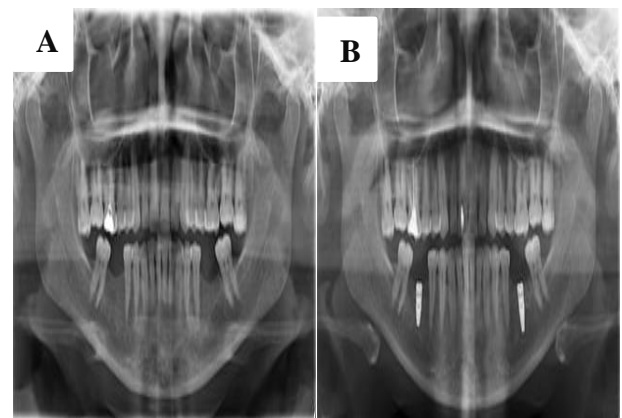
(A and B) Pre and post panoramic radiograph.
